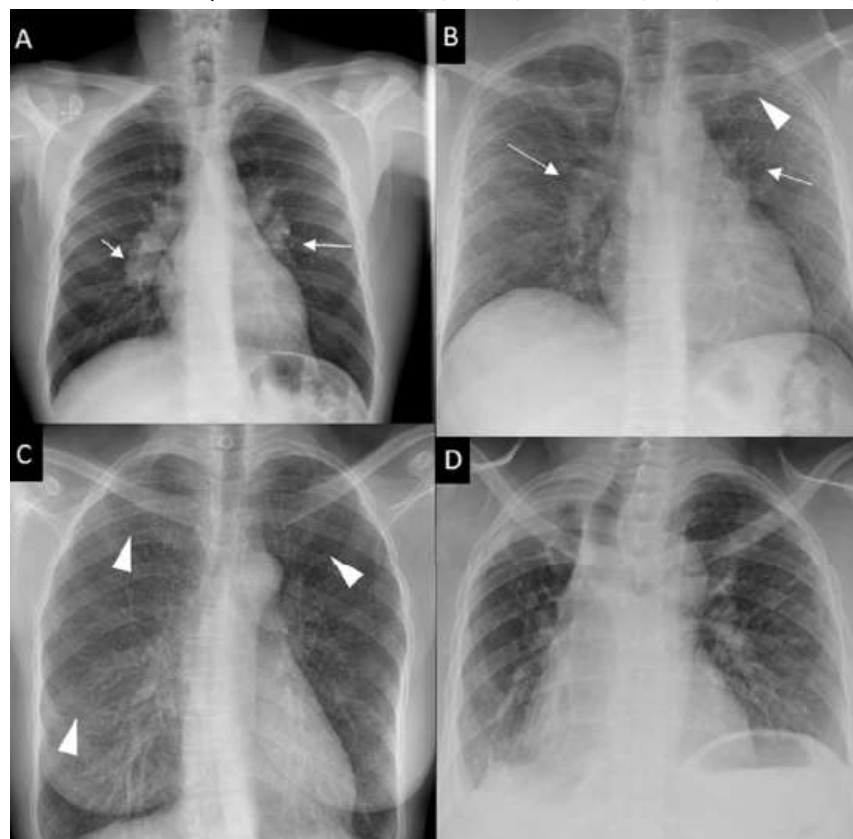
Scadding staging system chest x-ray. (A) Stage I bilateral hilar lymph node enlargement (white arrow), (B) Stage II bilateral hilar lymph node enlargement and left upper lobe infiltrate
